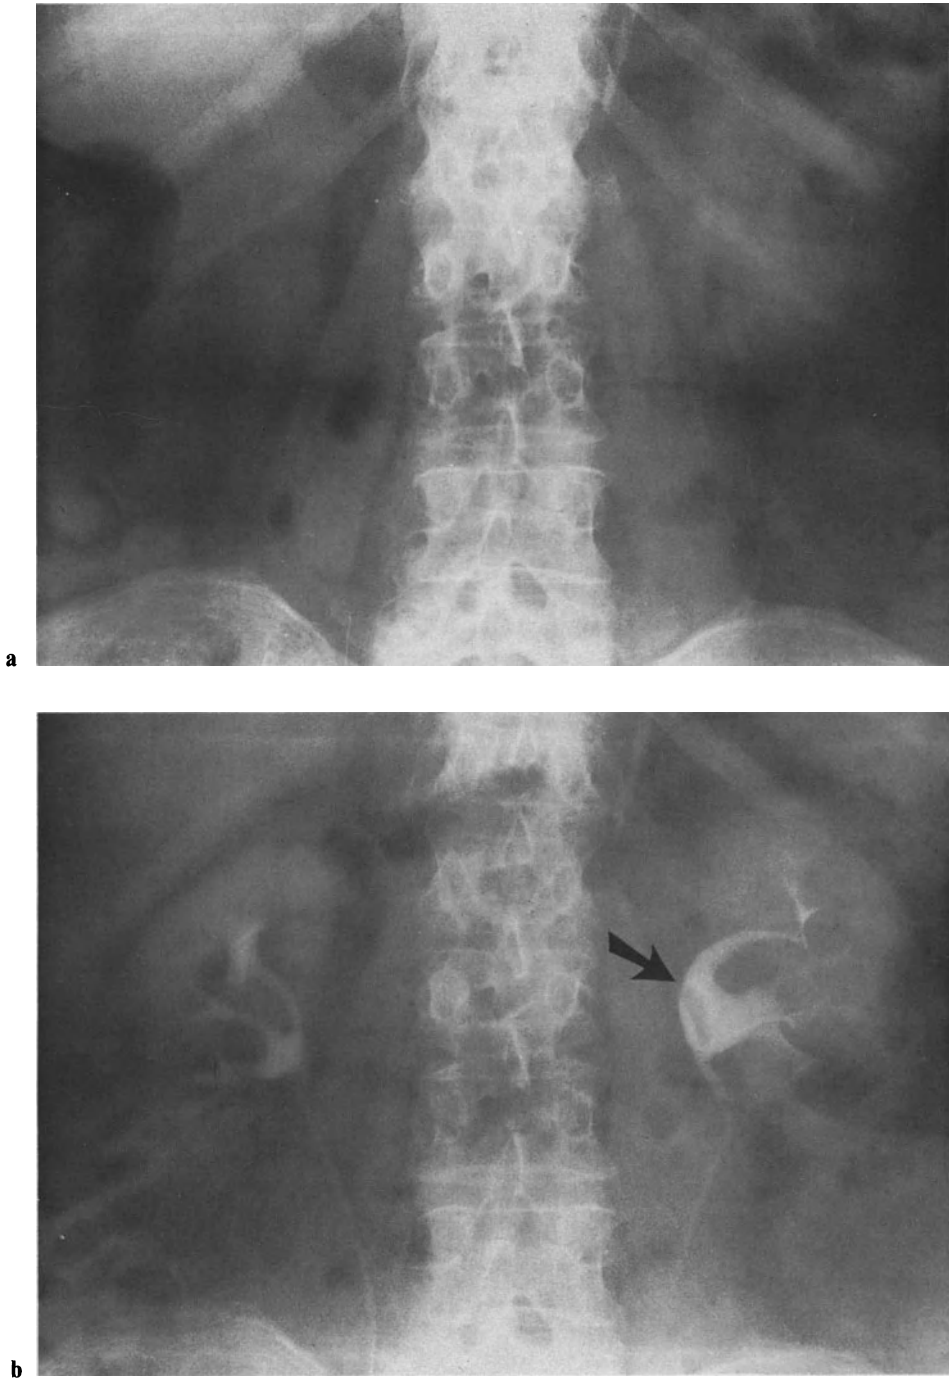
Non-opaque renal pelvis stone in the left kidney. a Plain film, b IVP with filling defect in the renal pelvis (*arrow*). c Sonogram with for stone (+ . . . +) typical sound-shadow, d CT scan showing unmistakably the stone in the renal pelvis (*arrow*); the renal pelvis is surrounded by fatty tissue
